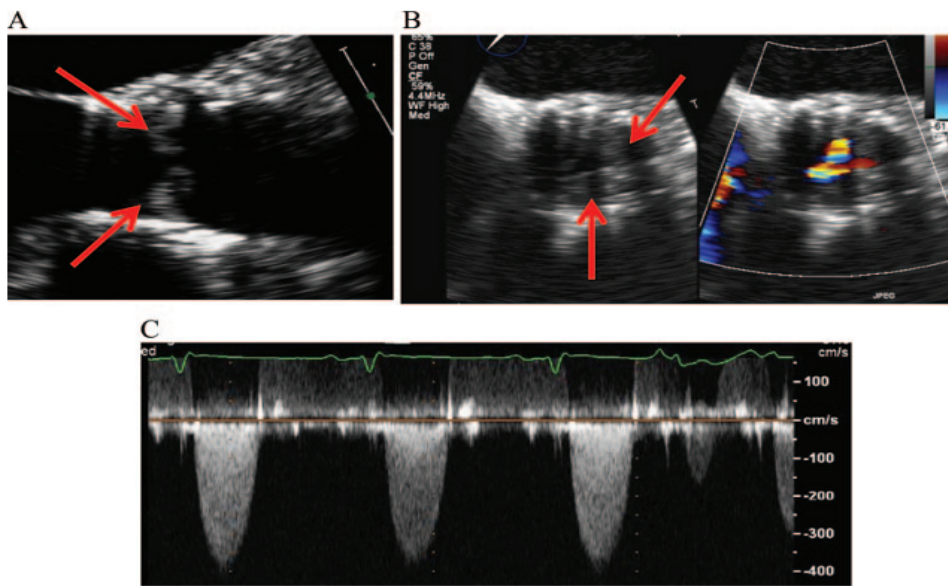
Transoesophageal echocardiography shows thickened leaflets (long-axis view [A] and short-axis view [B]) and severe stenosis of the Sapien valve (high transvalvular gradient [C]).
